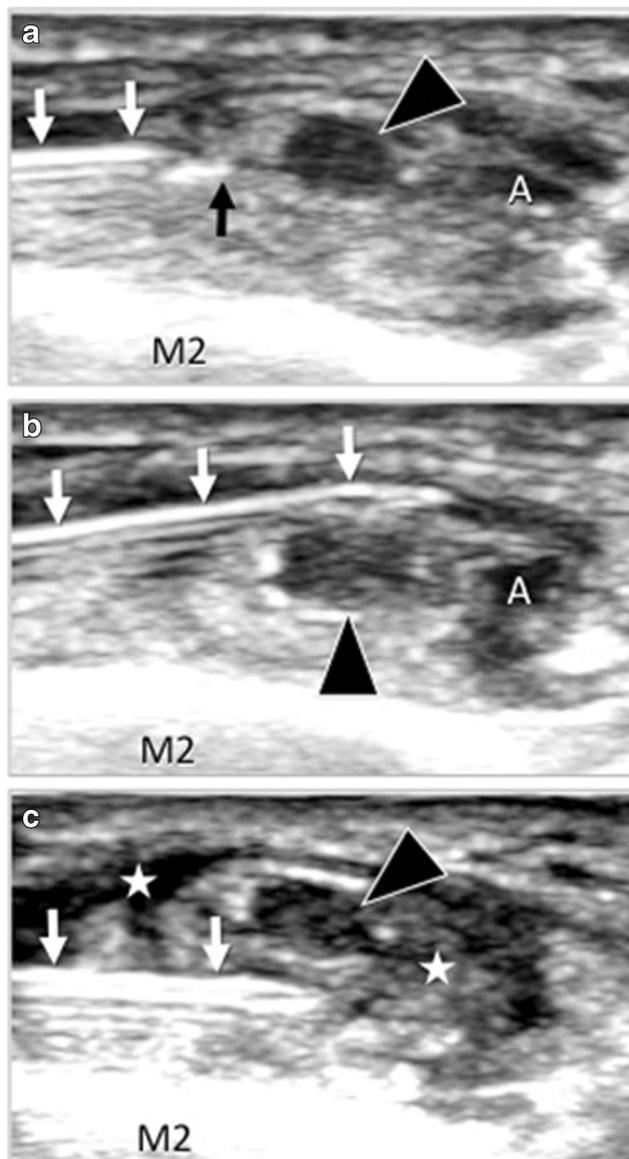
A 51-year-old woman with compression of the MBDFN at the Lisfranc joint (patient 2). Ultrasound guided local injection. Sequential sonograms were obtained during ultrasound (US)-guided perineurioma injection. a The needle (white arrows) was maneuvered under US guidance until the tip (black arrow) was close to the neuroma (arrowheads). b and c Note the sequential injection (b) over and (c) under the neuroma. Stars indicate the injected fluid surrounding the neuroma
